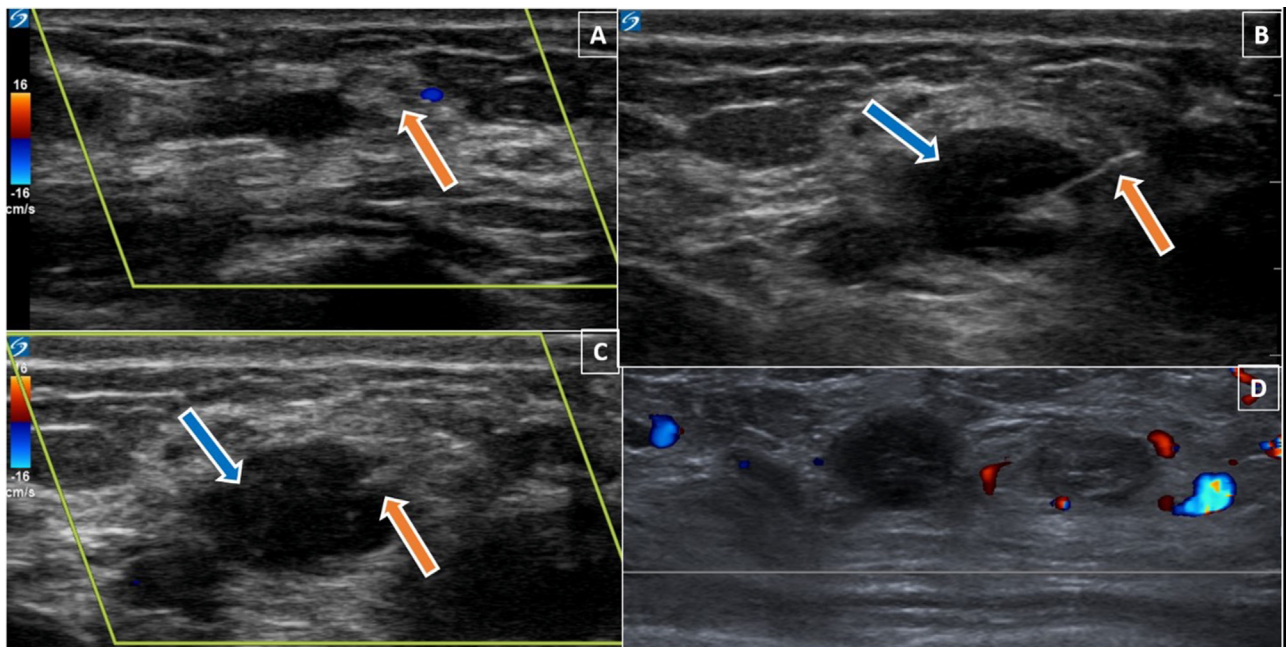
Image (A) demonstrates attempt at ultrasound-guided compression as initial treatment of pseudoaneurysm. Images (B) and (C) are images confirming needle position (orange arrows) for thrombin delivery within the pseudoaneurysm (blue arrows). Image (D) is the 24-hour follow up ultrasound after thrombin injection demonstrating 2 thrombosed pseudoaneurysms.
